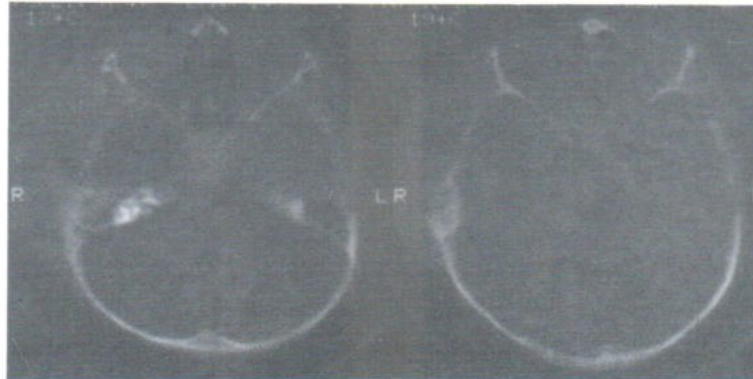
Case2. Bone window CT scan of the right temporal bone showed a mixed permeative lesion and an expanding osteolytic area with sclerotic rim.
